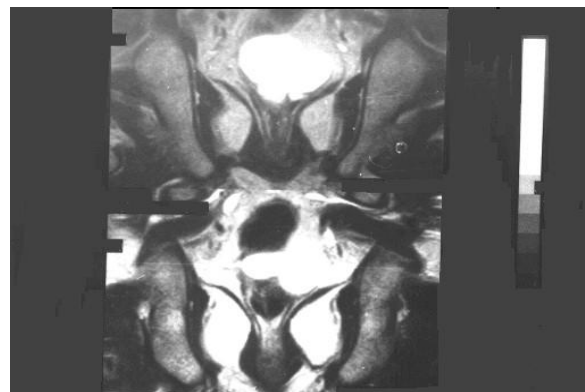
MRI (axial T₂-weighted image), coronal cut just posterior to the urinary bladder, reveals a large septated left seminal vesicle cyst (Case 1).
